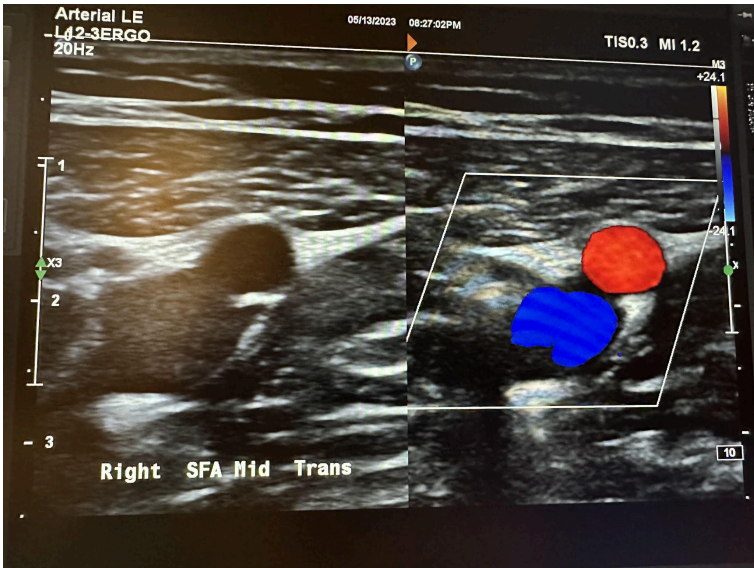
Side-by-side transverse images of the right middle superficial femoral artery without color Doppler and with color Doppler.
